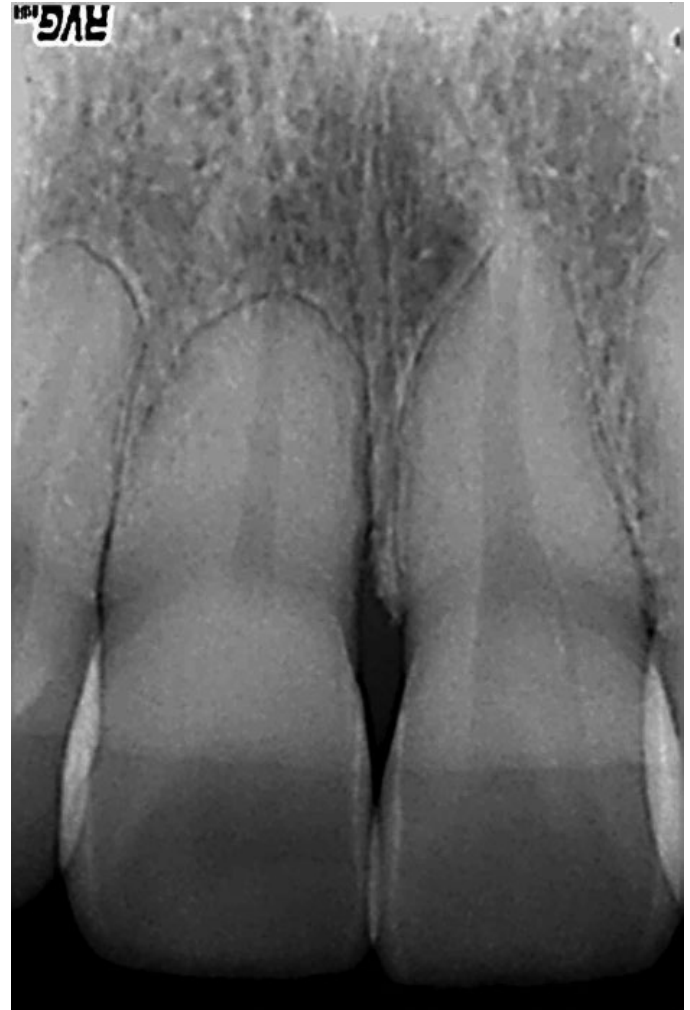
(B) Pretreatment periapical image of maxillary left central incisor with calcified pulp chamber.
